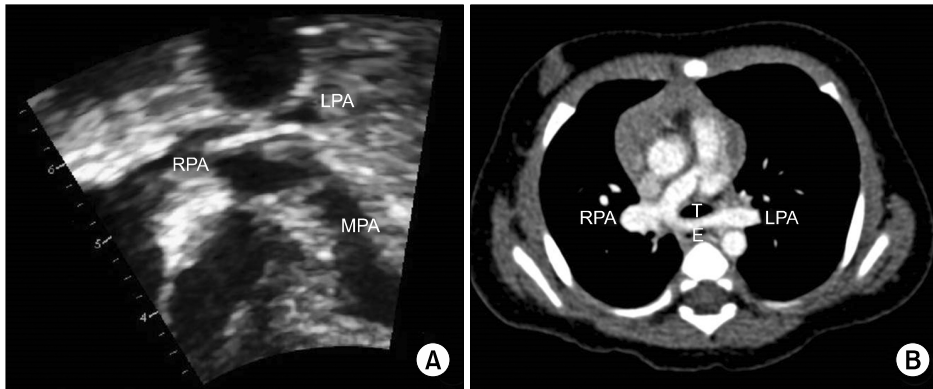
(A) Subcostal coronal view of a preoperative echocardiogram showing the hypoplastic MPA and LPA originating from RPA. (B) Pre-operative computed tomography showing the LPA originating from the RPA and coursing between the trachea and the esophagus. MPA, main pulmonary artery; LPA, left pulmonary artery; RPA, right pulmonary artery; T, trachea; E, esophagus.
